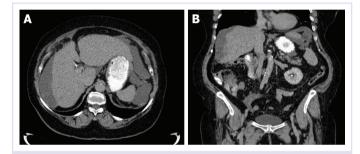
(A) Axial CT scan view of the abdomen, with the cystic masses in the right perihepatic and left paracolic area. (B) Coronal CT scan view of the abdomen, with the cystic mass located at the subdiaphragmatic area compresses the liver.
